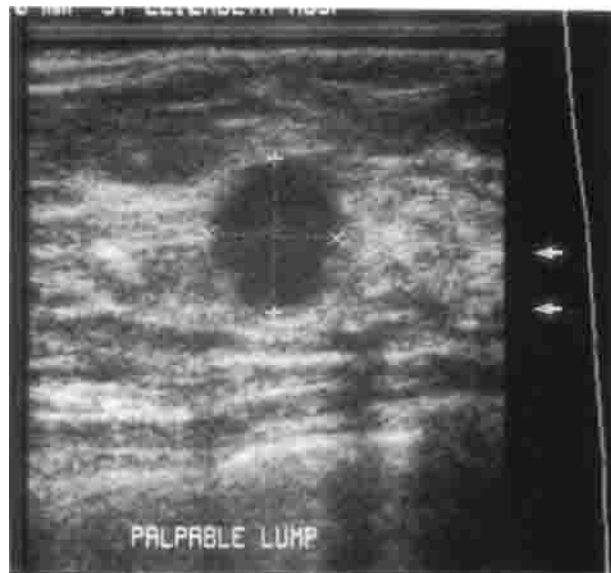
Ultrasonographic image showing hypoechoic mass with through transmission.
